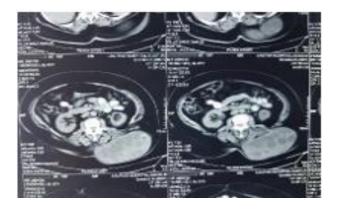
Plain CT abdomen showing swelling.
